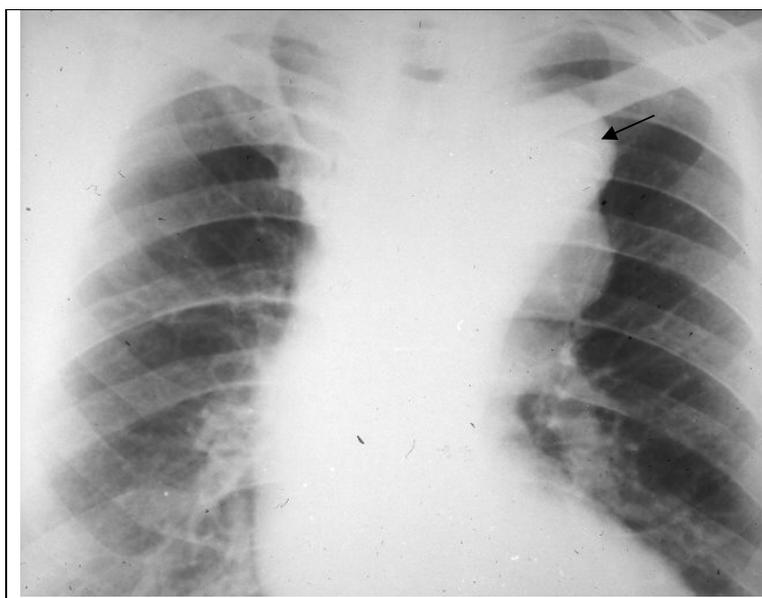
The frontal chest radiograph. The size of the aorta arch is sharply increased (arrow). Aneurysm of the aorta arch.
